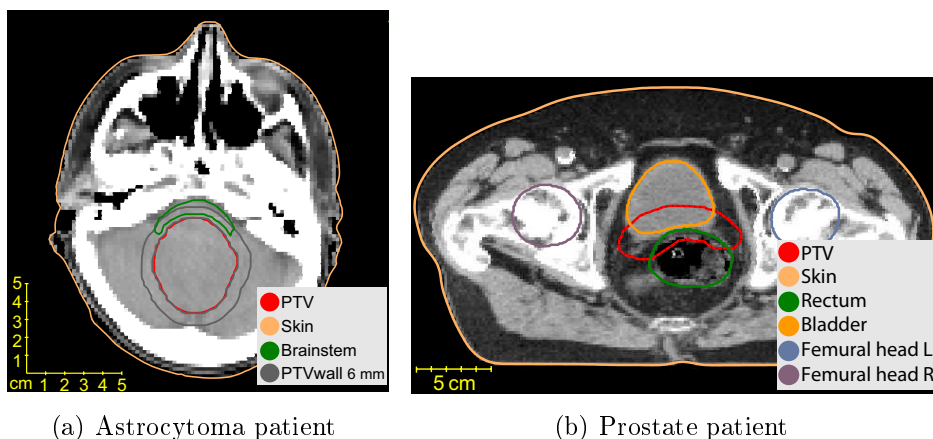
Astrocytoma and prostate patient: CT images and delineated contours.
